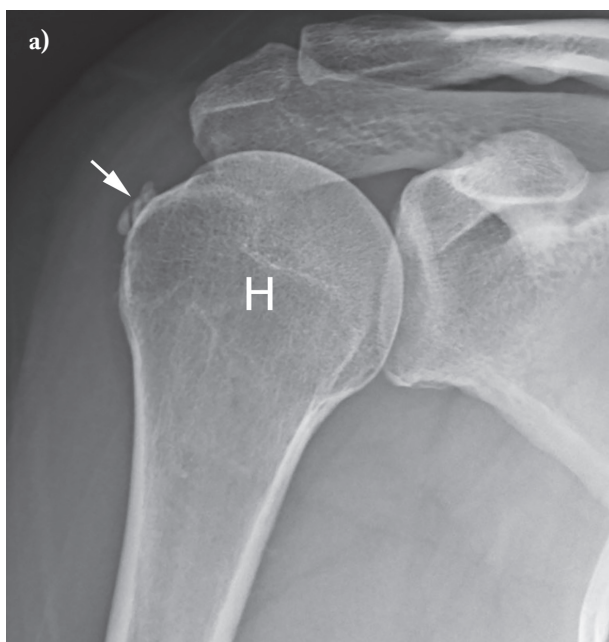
Calcific tendinopathy (arrow) of the supraspinatus tendon evaluated using (a) conventional radiography and (b) ultrasound in the same patient. The calcification has a maximum diameter of 7 mm. H=humeral
